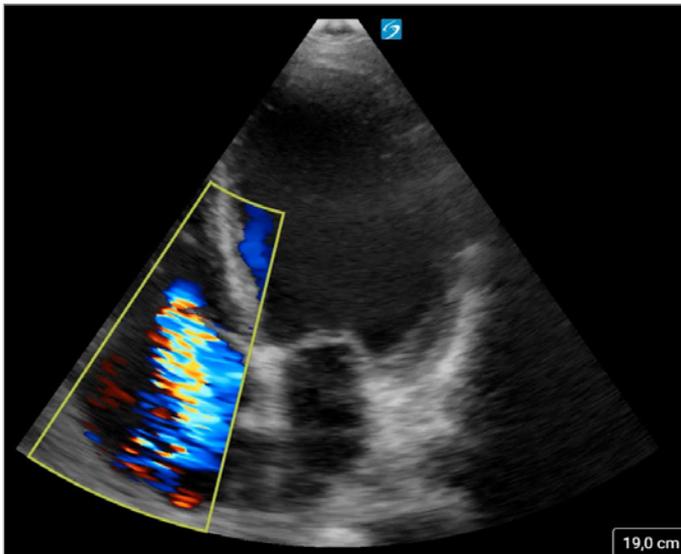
Point of care ultrasound. Apical 4 chamber view. Severe tricuspid insufficiency.
